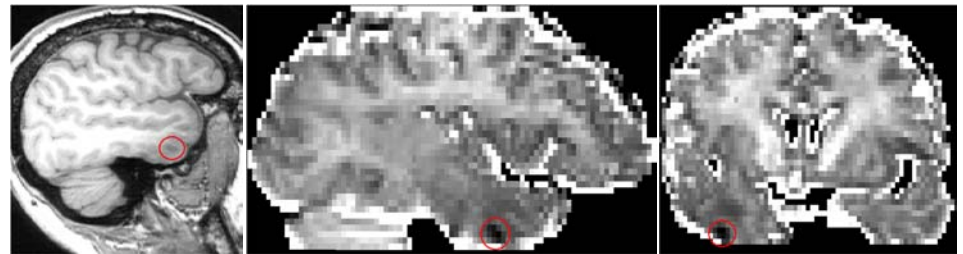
Tuberous sclerosis (tubers have the same pathology as FCD) - T1-weighted image (left) with corresponding reduced intracellular volume fraction (middle, sagittal and right, coronal)
